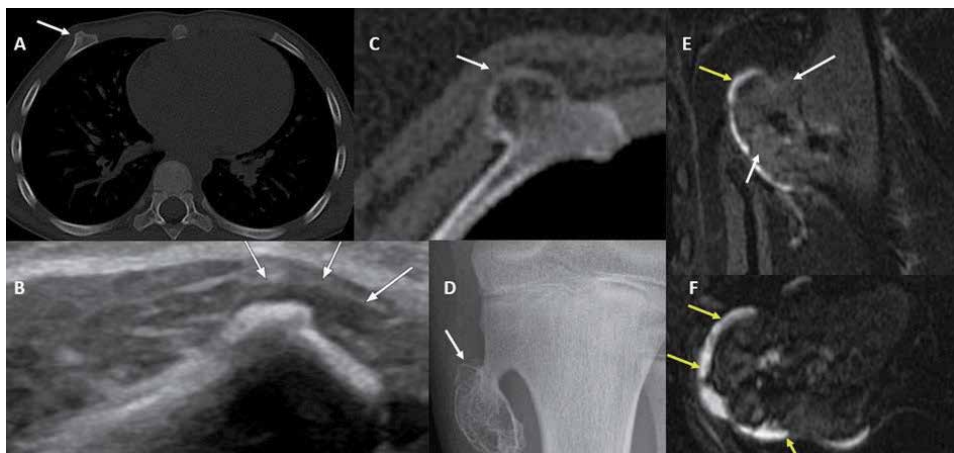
Osteochondroma: Axial CT bone algorithm image (A) of the mid thorax shows a focal bulge in the anterior right rib (white arrow) with cortical continuity, a finding also appreciated on the longitudinal grayscale ultrasound image (B). It represents a sessile osteochondroma, another example of which is C (white arrow). Frontal radiograph of the left tibia (D) reveals a pedunculated osteochondroma (white arrow) noted in the metaphyseal region, with the cortex of the parent bone (tibia in this case) contiguous with that of the lesion, and the lesion is directed away from the joint. The T2-weighted fat-saturated coronal (E) and axial (F) images reveal the T2 hyperintense cartilage cap (yellow arrows) of that osteochondral lesion (white arrows).
